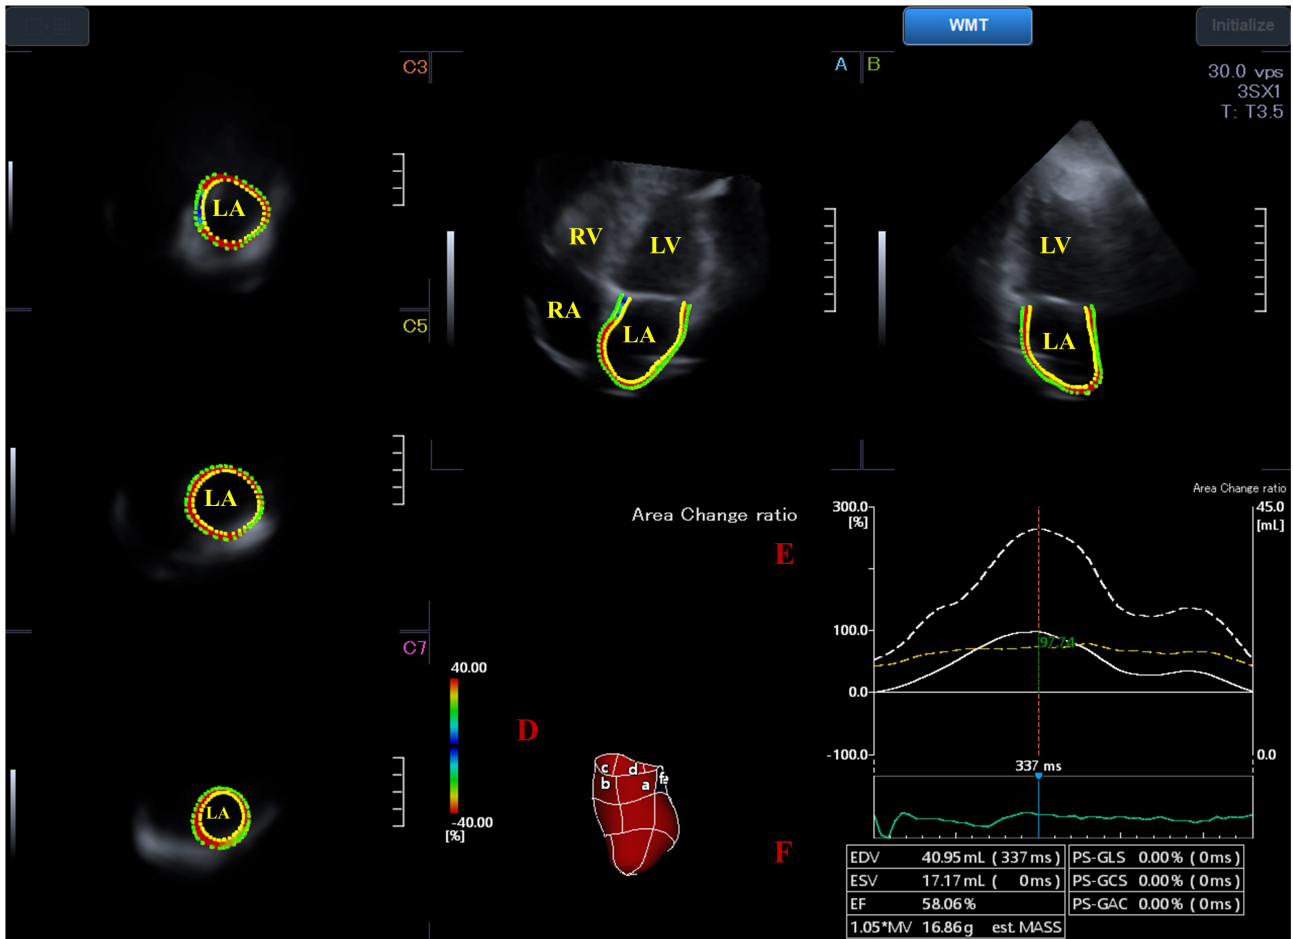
Three-dimensional (3D) speckle tracking echocardiography-derived full-volume dataset from which the 3D cast of the left atrium (LA) is extracted in a healthy subject. (A) Apical four-chamber view. (B) Apical two-chamber view. (C3) Short-axis view at basal LA level, (C5) short-axis view at midatrial LA level and (C7) short-axis view at superior LA level are presented (D) with a 3D virtual model of the LA. (E) Time-global LA volume change (dashed line) and time-global LA area change ratio (strain) curves (white line) with (F) calculated volumetric LA data are also shown. Abbreviations: EDV, LA volume at end-diastole; ESV, LA volume at end-systole; EF, LA ejection fraction; LA, left atrium; LV, left ventricle; RA, right atrium; RV, right ventricle.
